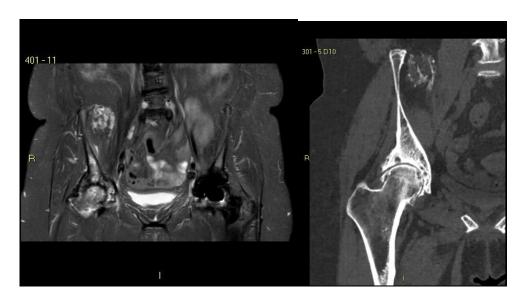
A. X-ray of the pelvis, showing a severe osteoarthritis of the right hip. B and C. MRI and CT scan of the same patient
